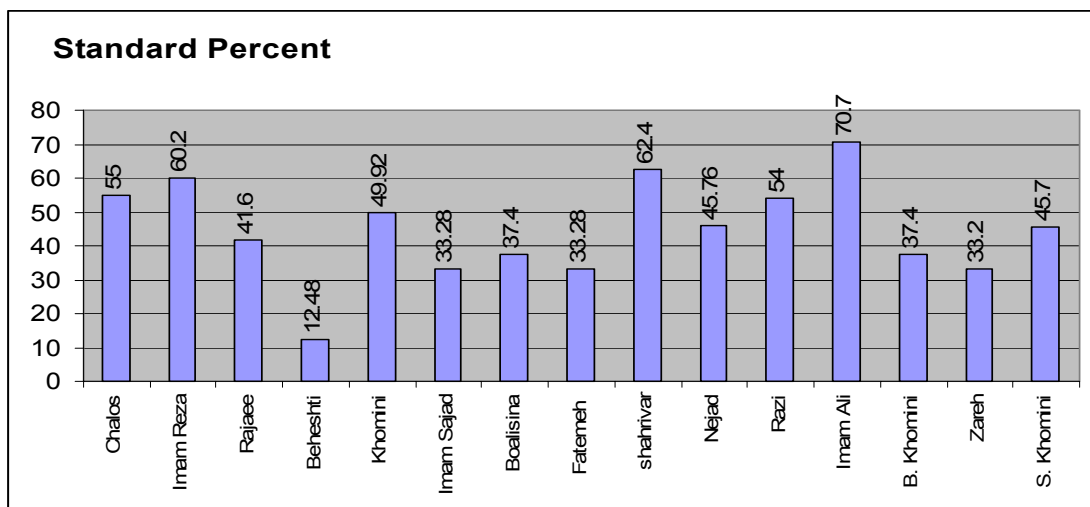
conditions dark room in the radiography unit considering the parameters under study.
